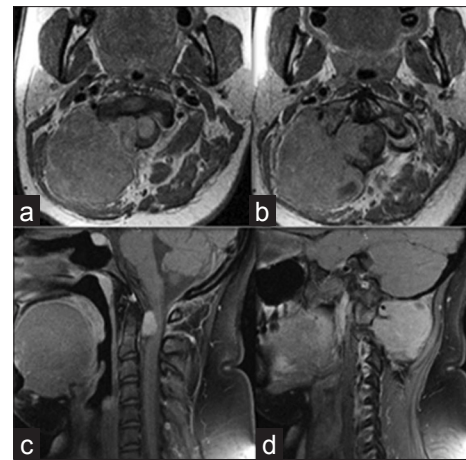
(a) Postgadolinium axial T1-weighted magnetic resonance imaging scan demonstrating intense enhancement of the lesion in the right posterior cervical region, with cervical spine extension. (b and c) intraspinal component compressing the spinal cord antero-laterally. (d) tumoral invasion through right foramina of atlas and axis
